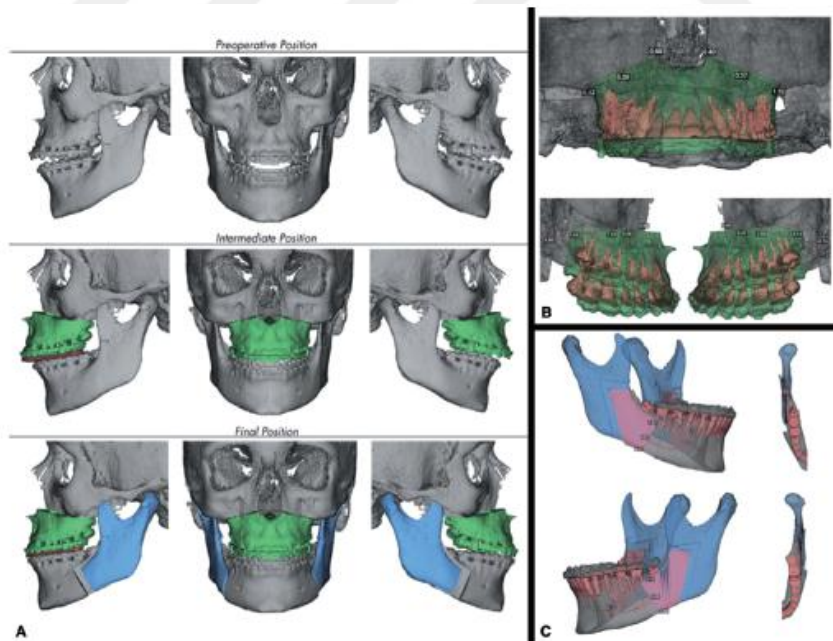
3D Virtual planning of orthognathic surgical plane (Cone Beam Computed Tomography/ Sarmant D 2014).
